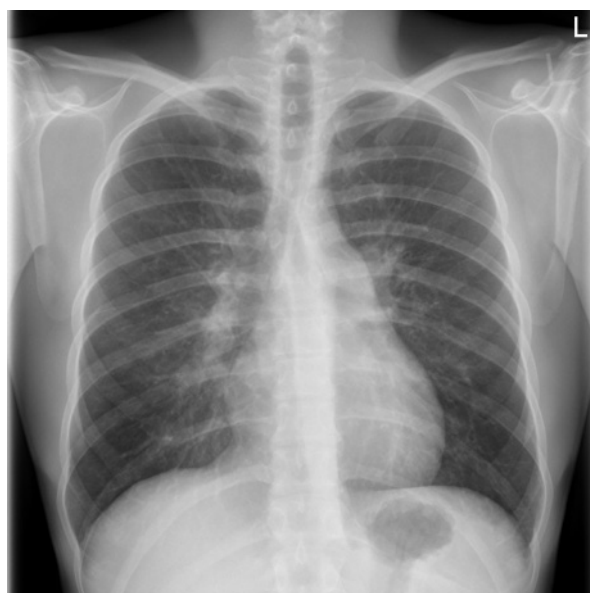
Chest X-ray: Linear interstitial diffused lesions in both lungs
